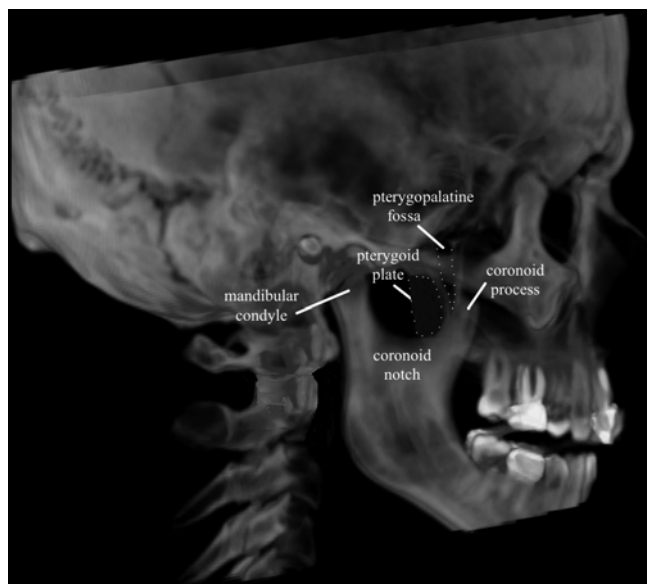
Lateral skull X-ray showing fluoroscopic landmarks (Image courtesy of Andrea Trescot, MD)
